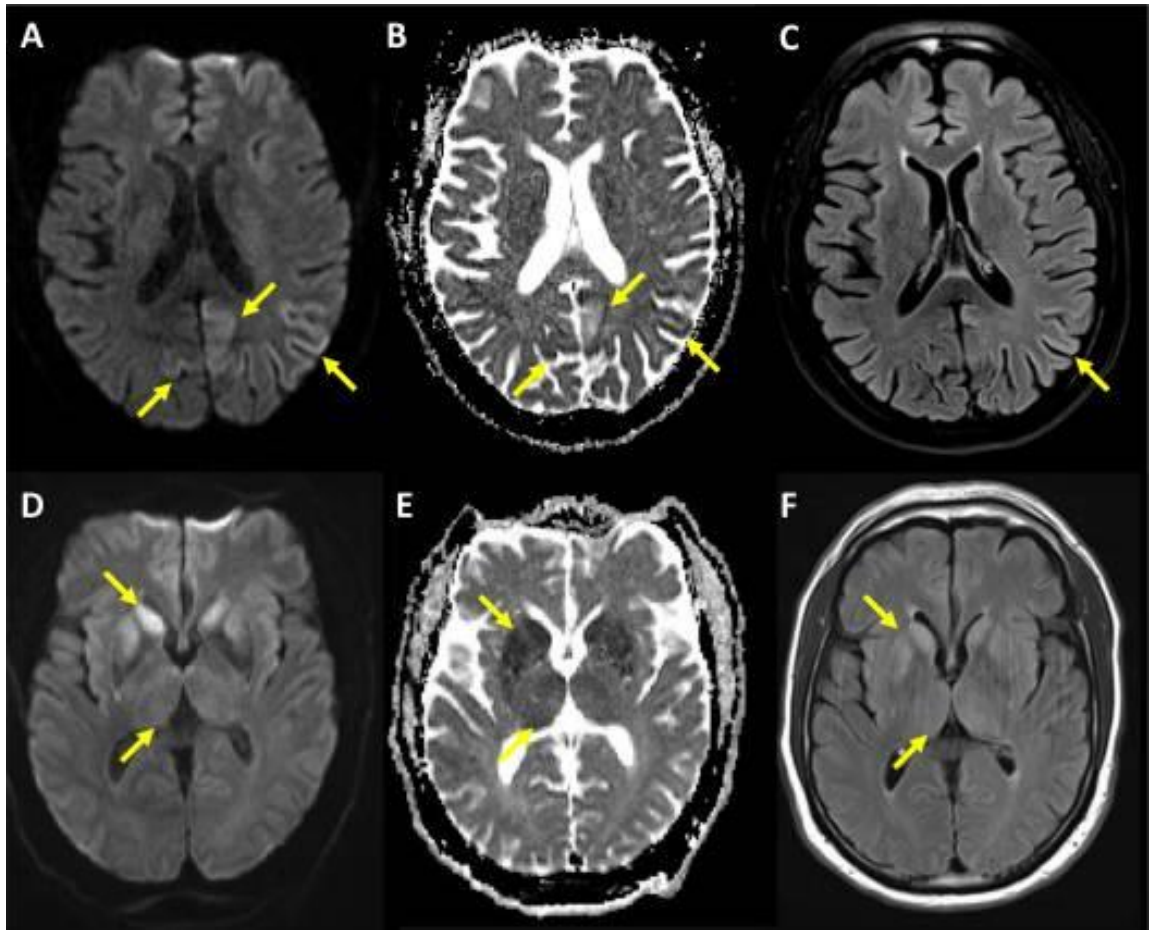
Pathologic changes characteristics on MRI sCJD patients.
